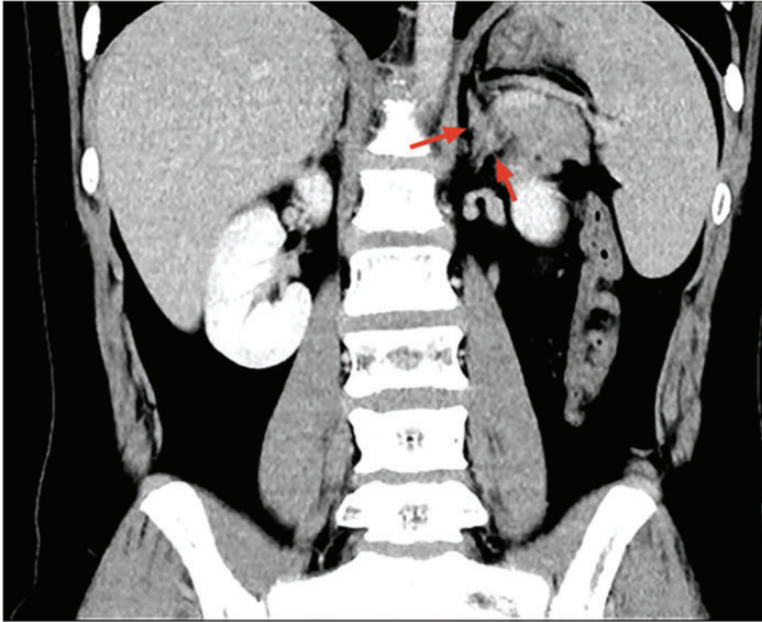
Abdominal enhanced computed tomography scan showed thickening of the left adrenal junction and the medial limb bulging outward (red arrows).
